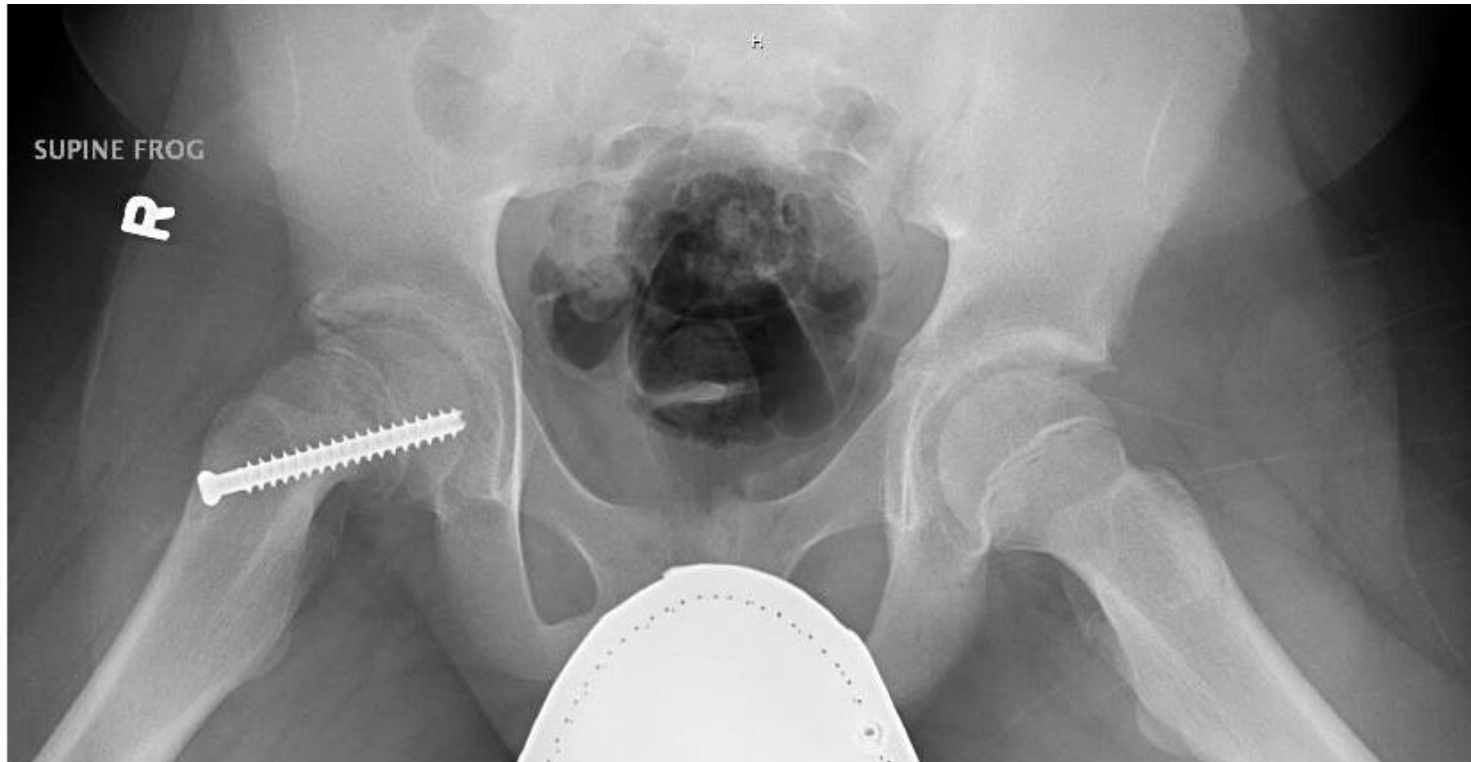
Post-operative frog lateral x-ray of the patient in Figure 3 demonstrating in situ fixation of right SCFE.
